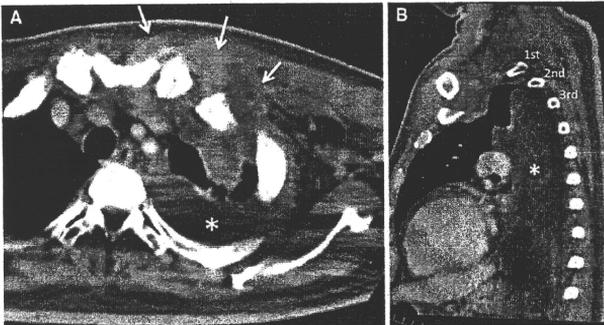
Axial CT and sagittal reconstruction showing the loculated pleural fluid extending to pulmonary apex in posterior part of thoracic cavity. Arrows septic arthritis of left sternoclavicular joint complicated with pyoderma of anterior chest wall. Asterisk loculated pleural fluid
